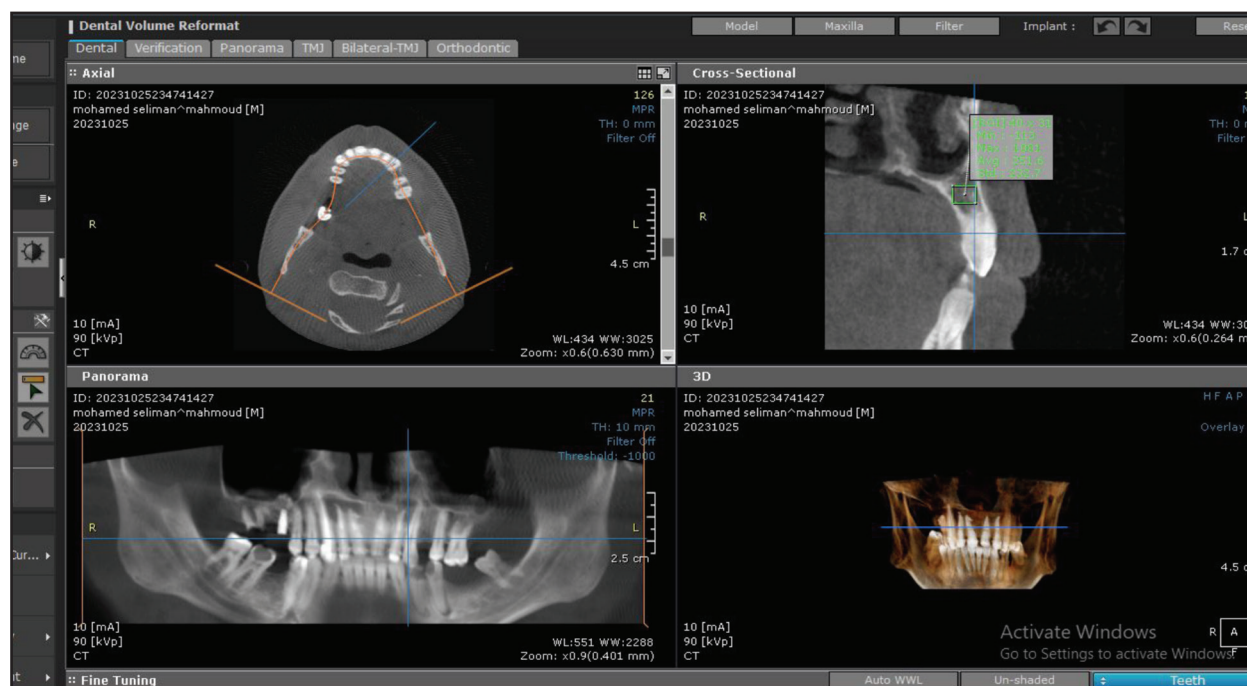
Cystic lesion on CBCT
